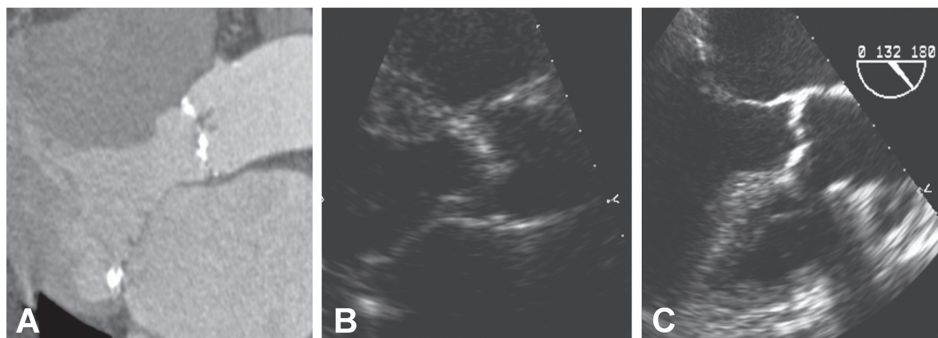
The (A) single oblique sagittal view on MSCT is equivalent to the (B) parasternal long axis-view on TTE and the (C) midesophageal long-axis view on TEE. The aortic annular measurements for this patient were 23, 23, and 24 mm respectively.
